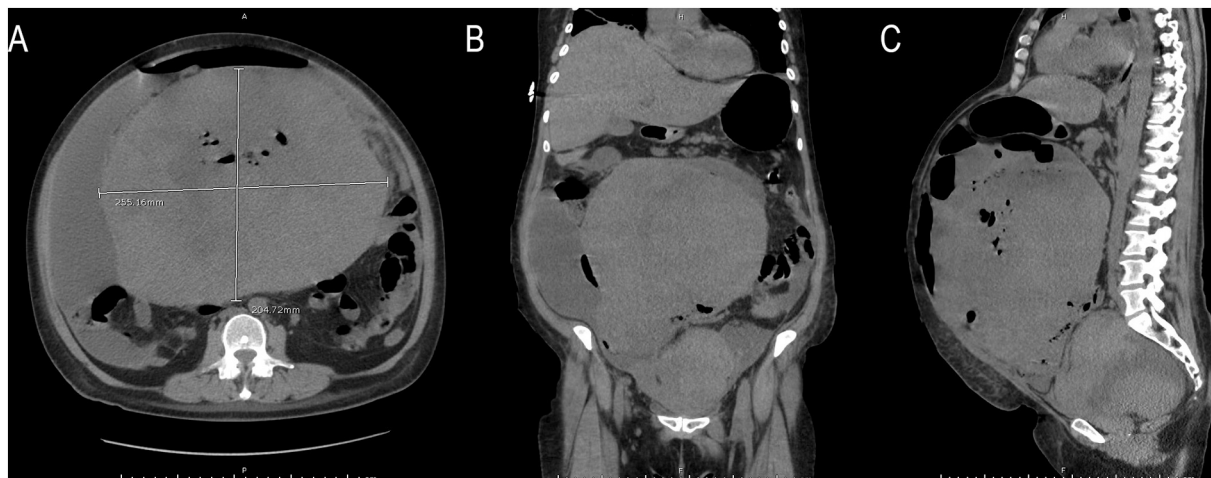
CT images of the abdomen and pelvis upon patient presentation: (A) axial, (B) coronal, (C) sagittal views. CT images demonstrate a large intra-abdominal mass occupying the majority of the abdomen. There was also evidence of free air consistent with bowel perforation.
